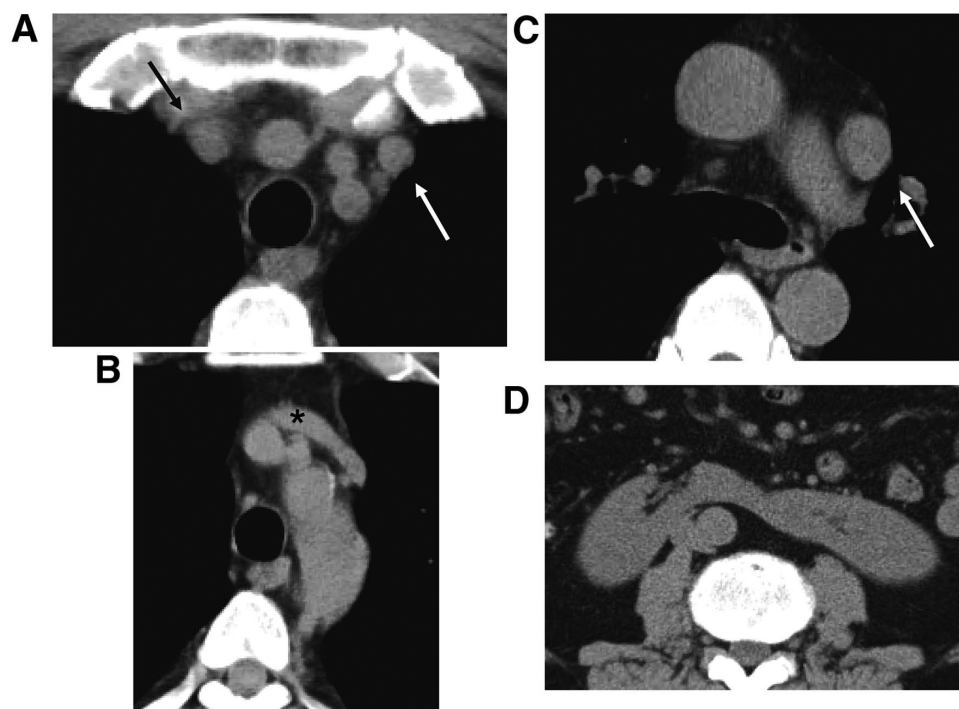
A 67-year-old male with a persistent left superior vena cava (SVC) and an absent right SVC associated with a horseshoe kidney. (A–C) Chest computed tomography (CT) images without contrast enhancement reveal a persistent left SVC (white arrow) and 2 bridging brachiocephalic veins (black arrow, *). (D) Abdominal CT shows fusion of the lower poles of the kidneys.
